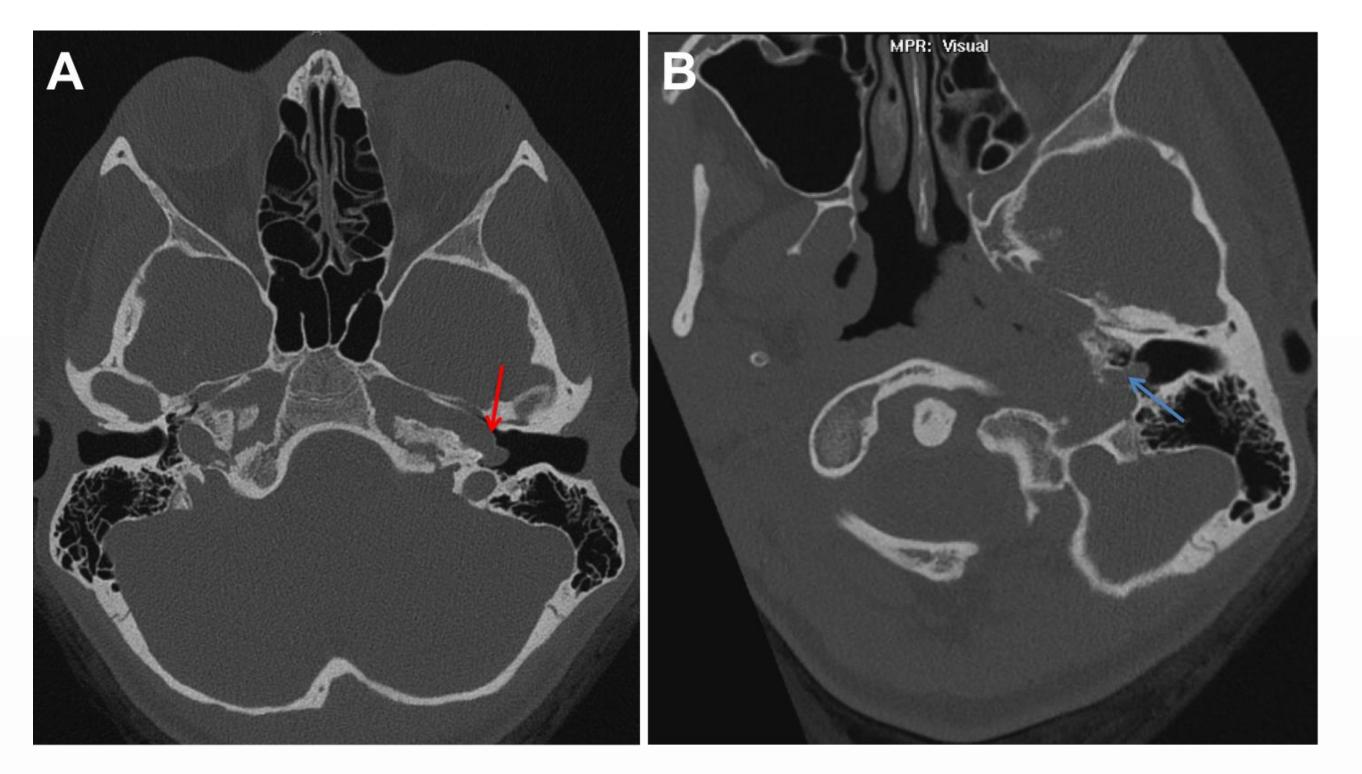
(a) Axial unenhanced CT through level of left external auditory canal demonstrates an abnormal tubular structure running along the medial aspect of the left middle ear, suspicious for aberrant ICA (red arrow). (b) Axial reformatted bone CT demonstrates the jugular bulb and soft tissue density mass within the inferior left middle ear cavity contiguous through the apparent dehiscent jugular plate (blue arrow) making it difficult to differentiate from aberrant ICA without intravenous contrast.
